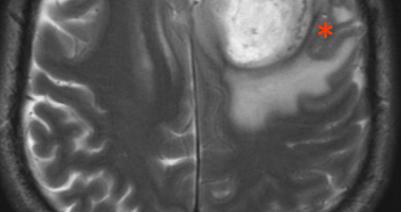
T2-weighted image demonstrates the characteristic radiological sign of intra-axial tumours (here a glioblastoma): outward displacement of the grey mater (red asterisks) and the CSF (yellow line) of the subarachnoid space.
